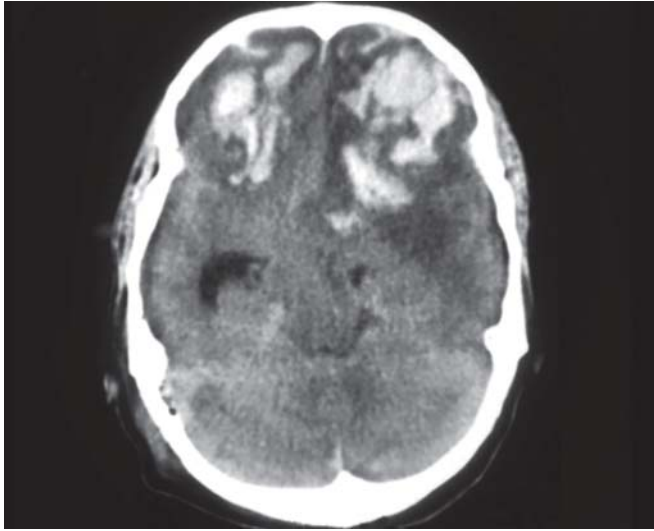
CT scan showing bilateral cerebral contusions
